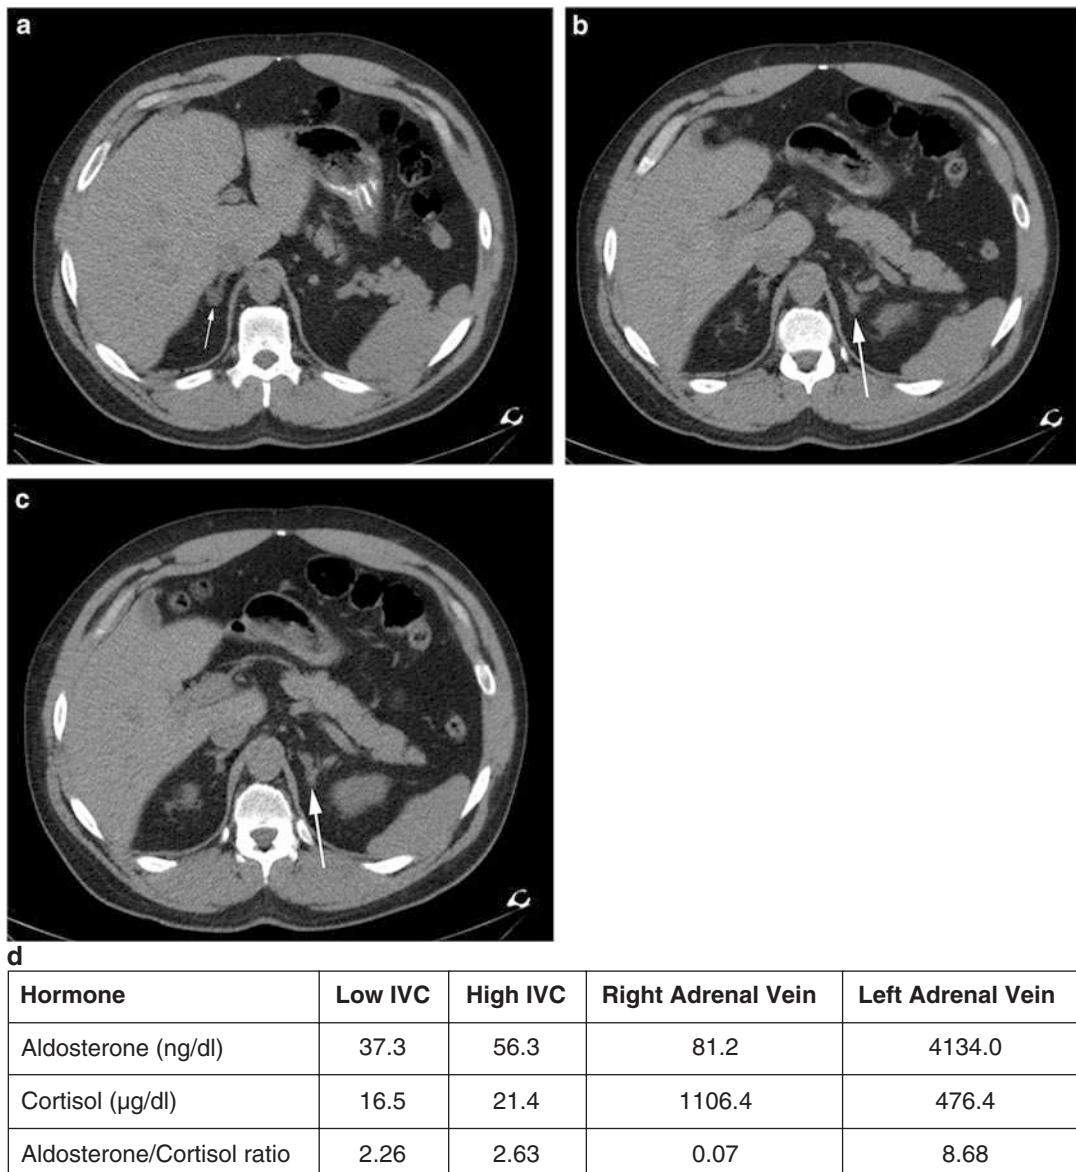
(a) CT image demonstrating a 1.4 cm right adrenal mass, which measured 3 HU (arrow) in a 48-year-old patient with primary hyperaldosteronism. (b, c) CT images from the same patient demonstrating increased thickness of the left adrenal gland without a well-defined
